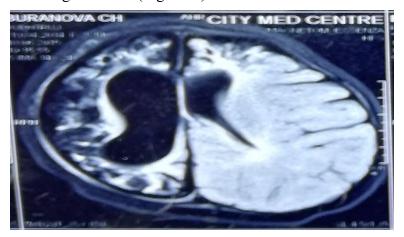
MRI of Patient K. Dilated lateral ventricles are seen which have shrunk several times, but atrophy and scar process persisted.
